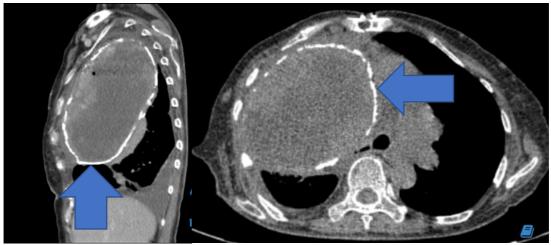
Thoracic CT scan showed a cystic lesion
